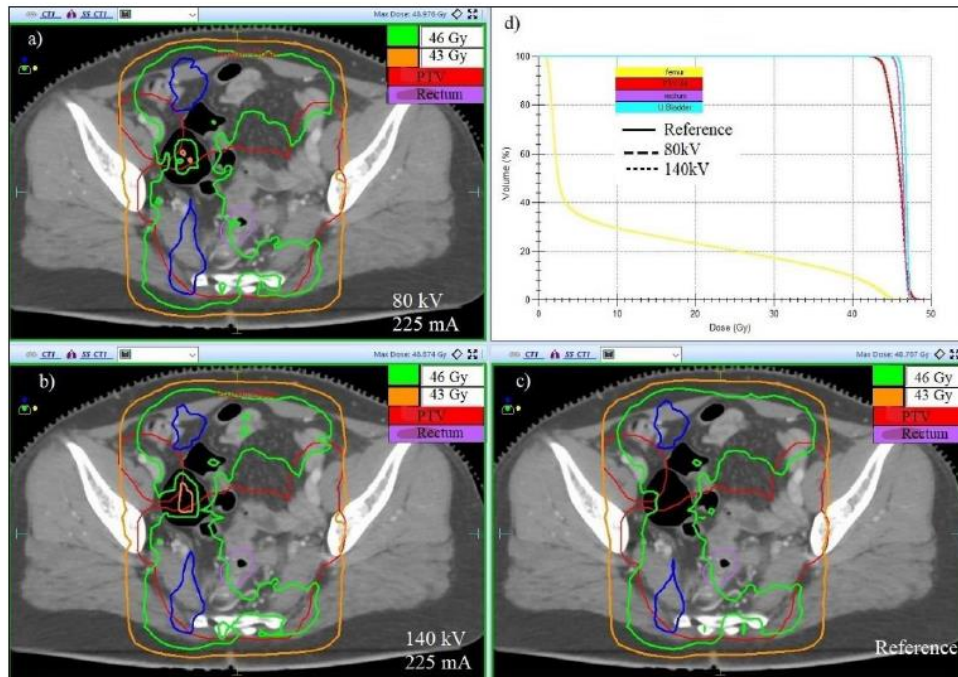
The pelvis CT scan of a patient showing the differences in distribution of 46 Gy and 43 Gy isodose lines at CT to RED curve of 80 kV 225 mA (a), 140 kV, 225 mA (b), reference curve (c) and comparative DVH (d).
